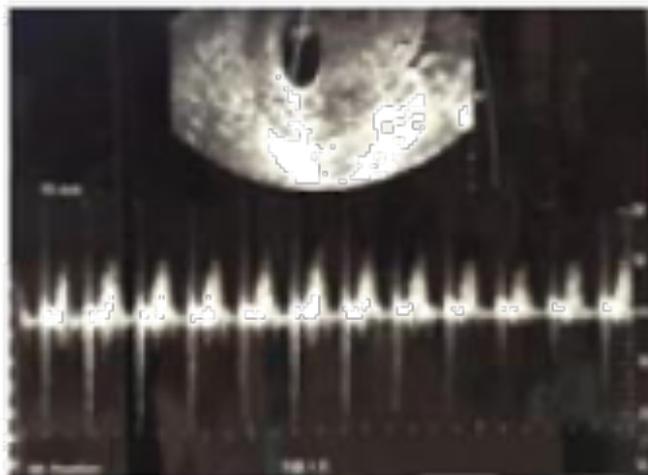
A Doppler ultrasound of a viable intrauterine pregnancy.
